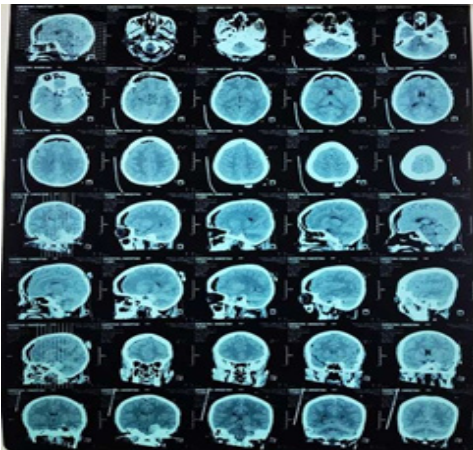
MRI Scan of Patient. MRI Diagnostics Showed an Extraaxial Solid Mass at the Meckel's Cave Area causing Transtentorial Herniation and Involving the Trigeminal Nerve
